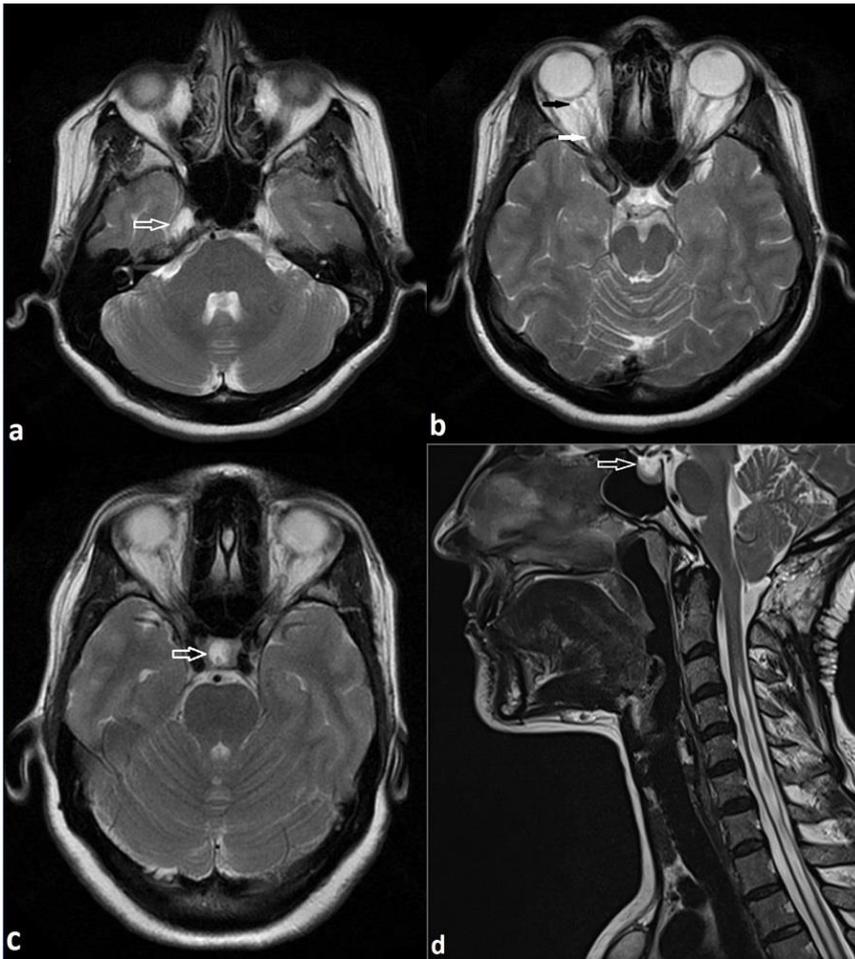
Radiological assessment of pseudotumor cerebri (PTC) presence from cerebral MRI images. (a) Expansion in Meckel's cave; (b) tortuosity of the optic nerve sheath (white arrow) and widening of cerebrospinal fluid space adjacent to the optic nerve (black arrow); and (c, d) empty sella syndrome.
